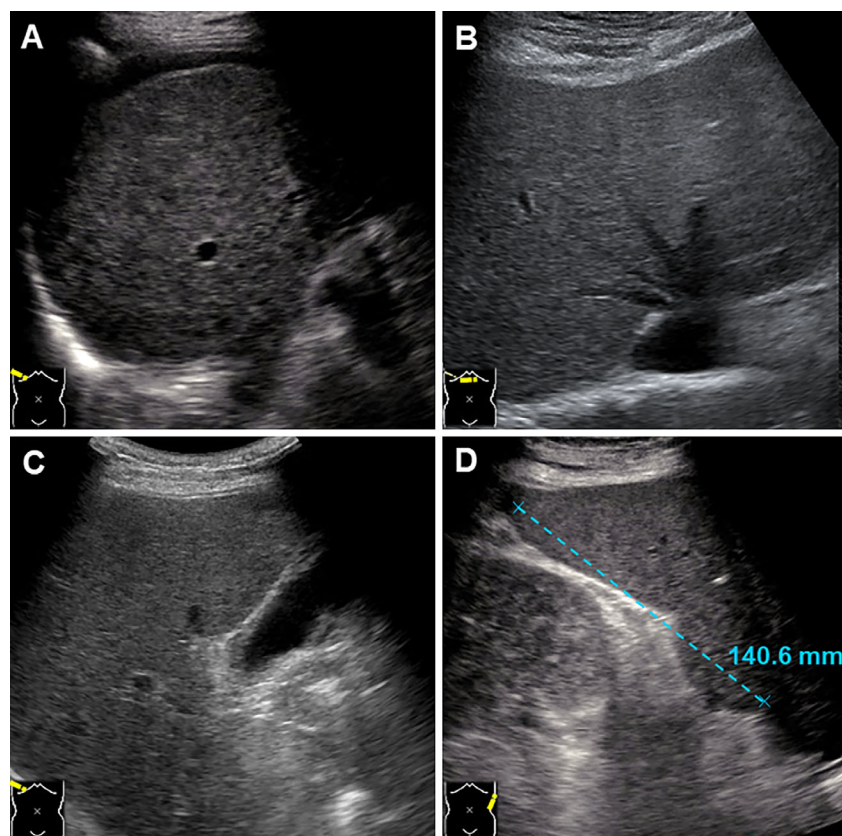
Ultrasonography findings of the abdomen. Ascitic fluid accumulation on the liver surface was observed. No signs indicating liver cirrhosis, intrahepatic masses, bile duct dilatation, or biliary obstruction were detected (A-C). Splenomegaly with a maximum diameter of 140.6 mm was noted (D).
